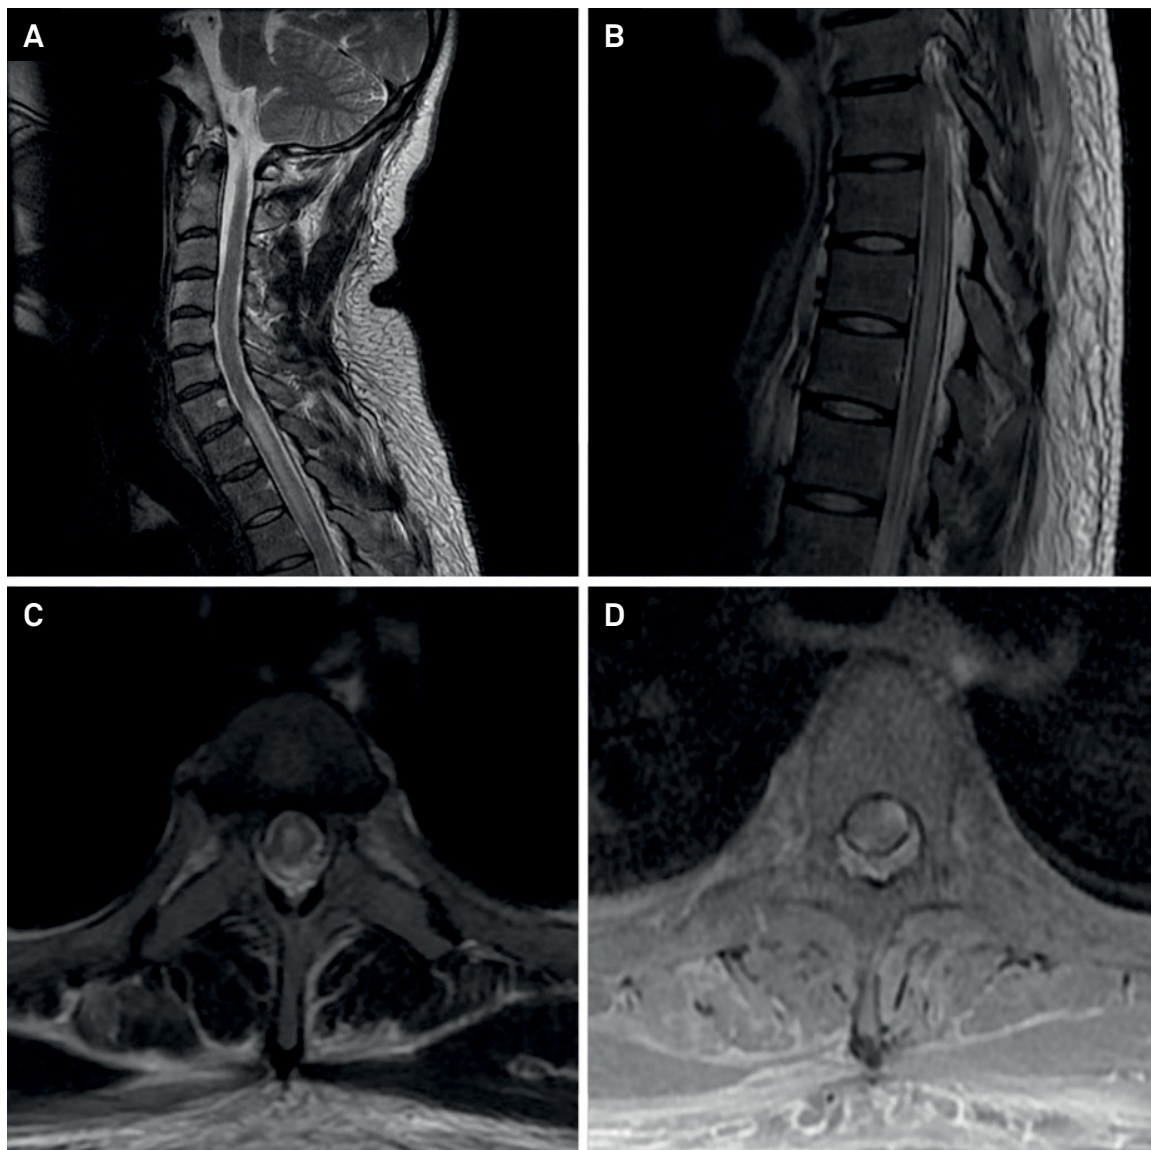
MRI of the vertebral column of a patient with transverse myelitis caused by neurosyphilis. A and B: Sagittal T2-weighted images of cervicothoracic vertebral column showing a hyperintense lesion affecting spinal cord segments from C6-C7 to T11-T12; C: Axial T2-weighted MRI showing hyperintensity involving most of the circumference of the spinal cord; D: Axial T1-weighted post-gadolinium MRI showing contrast enhancement in two different areas of the spinal cord.
